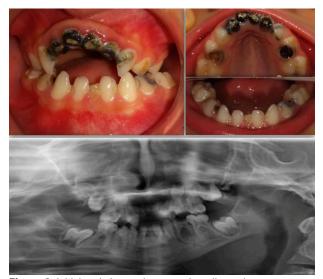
Initial oral view and panoramic radiograph.
